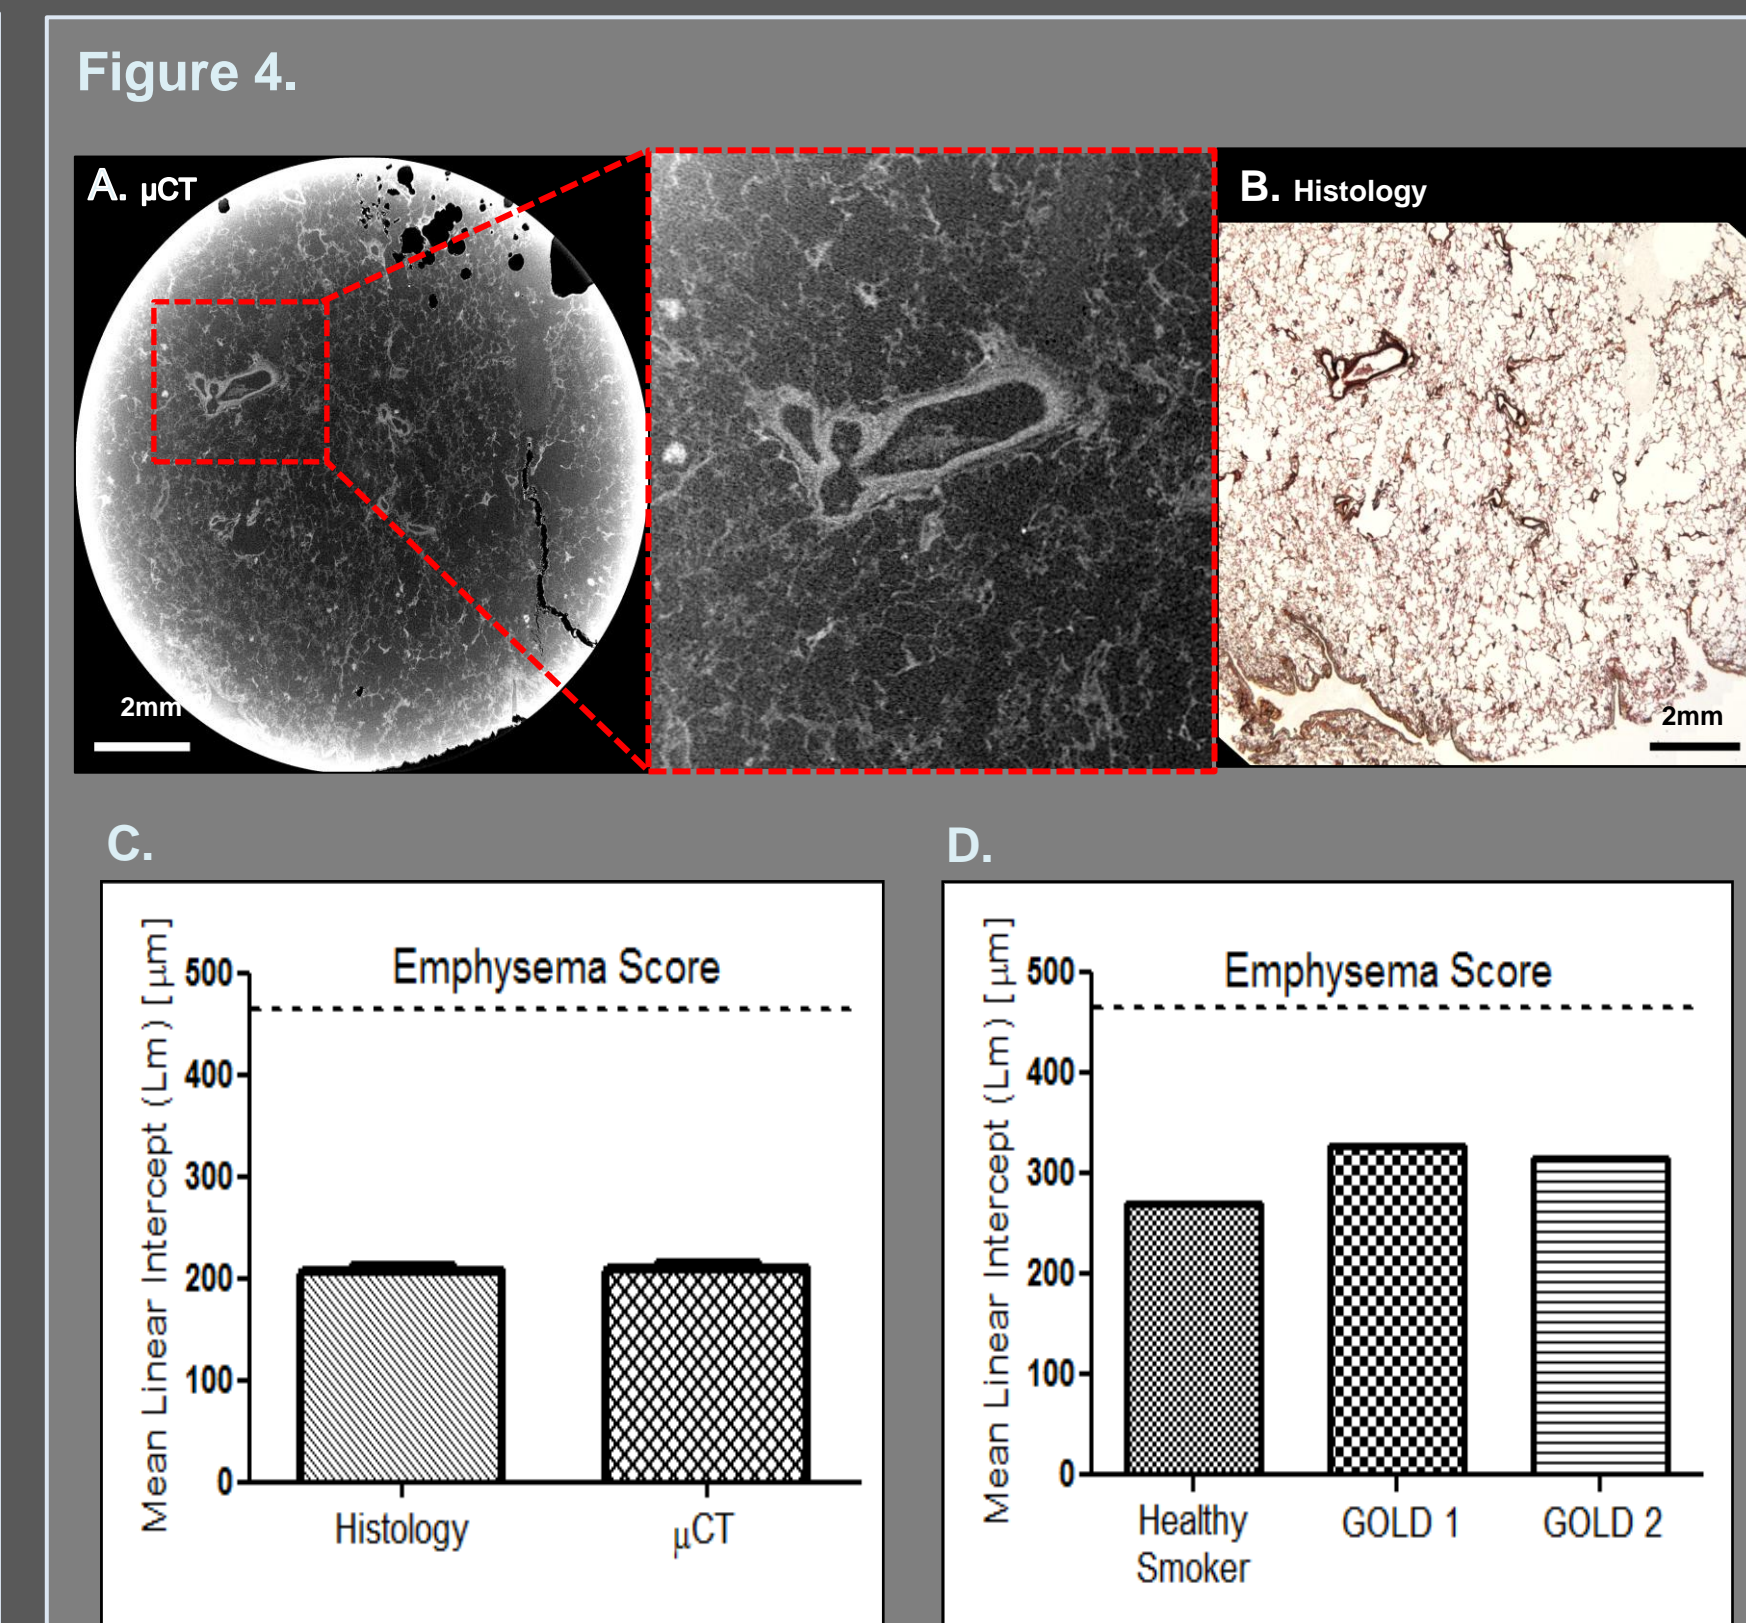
$\mu$ CT images allow visualization of small airways <2mm in diameter in FFPE samples.
